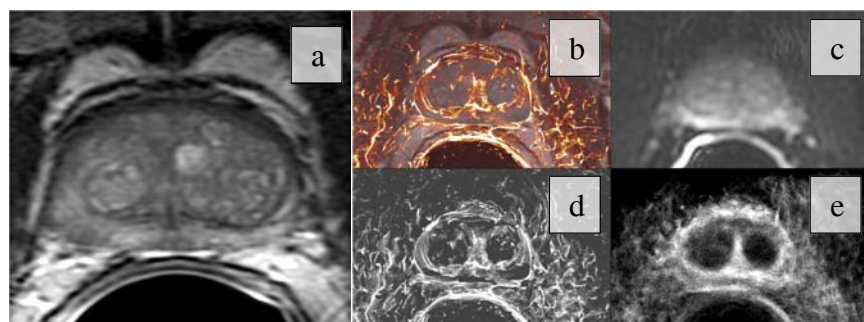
62 yo with biopsy-proven G3+4 tumor managed by active surveillance. Sample slice without visible tumor. a: T2 axial b: T2 with TDI overlay, d: DWI, e: TDI with DTI tractography, e: TDI with HARDI tractography
